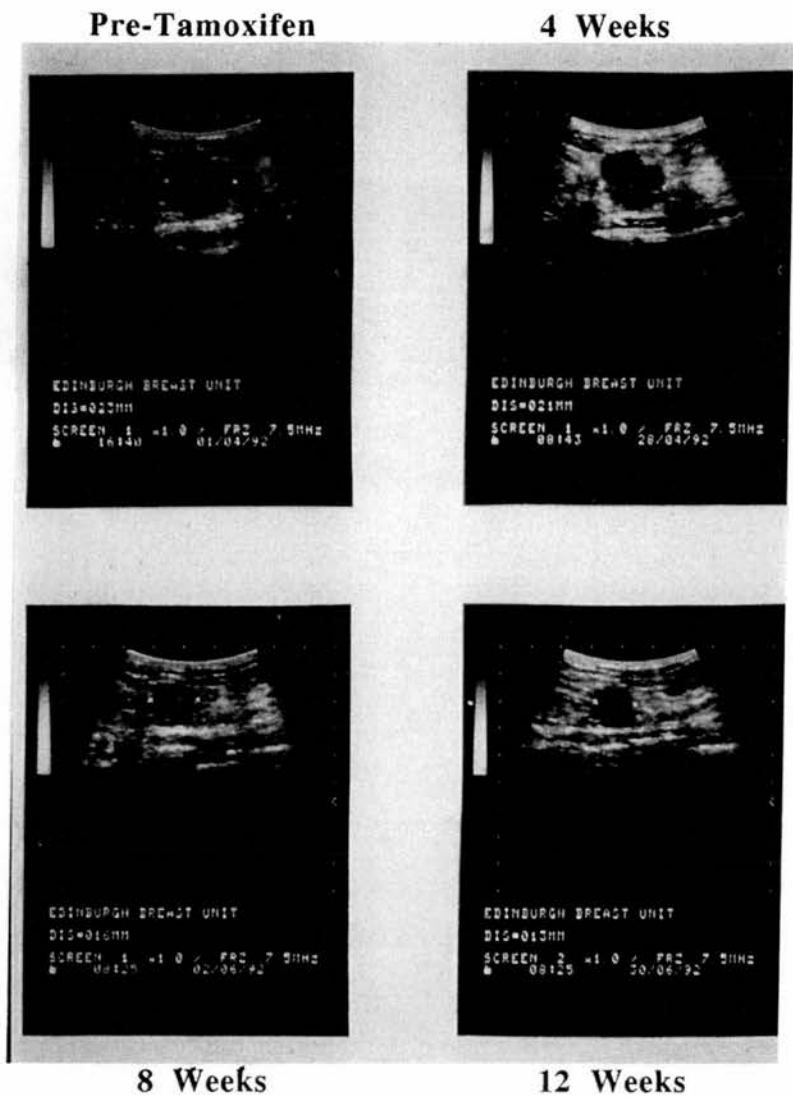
shows a series of four ultrasound scans taken before treatment and then at four-weekly intervals thereafter. The tumour is demonstrated as a hypoechoic roughly circular region in the centre of each scan with typical wall “shadows”. The tumour diameter, in the single plane view shown, as determined by electronic callipers is recorded below each scan.
